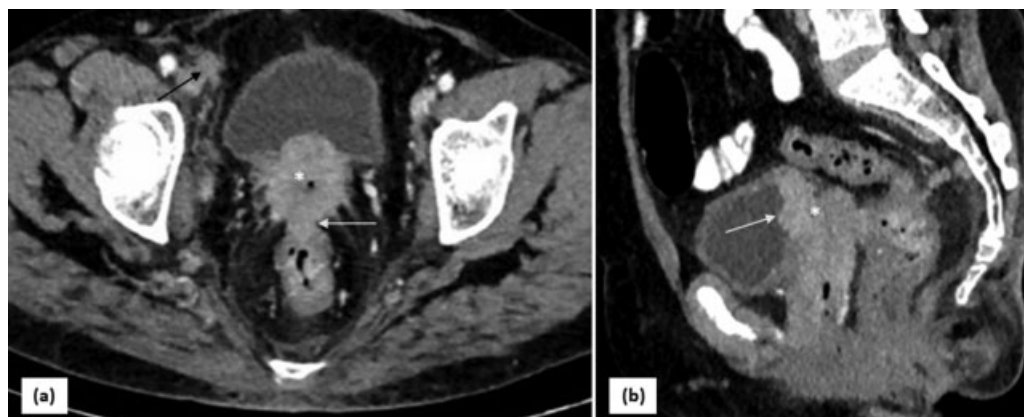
CT in recurrent carcinoma cervix—(a) Postoperative follow-up axial CT image shows an irregular recurrent growth in the vault (*asterisk*) which is infiltrating the rectum posteriorly (*arrow*). (b) Sagittal reformatted image shows infiltration of the posterior wall of urinary bladder (*arrow*) by the mass. Enlarged lymph node with irregular margins is seen along right external iliac vessels (*black arrow* in a).
